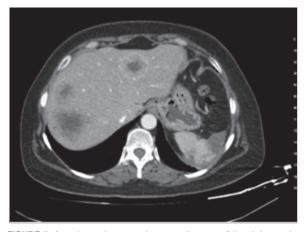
An enhanced computed tomography scan of the abdomen demonstrating multiple metastasis.
